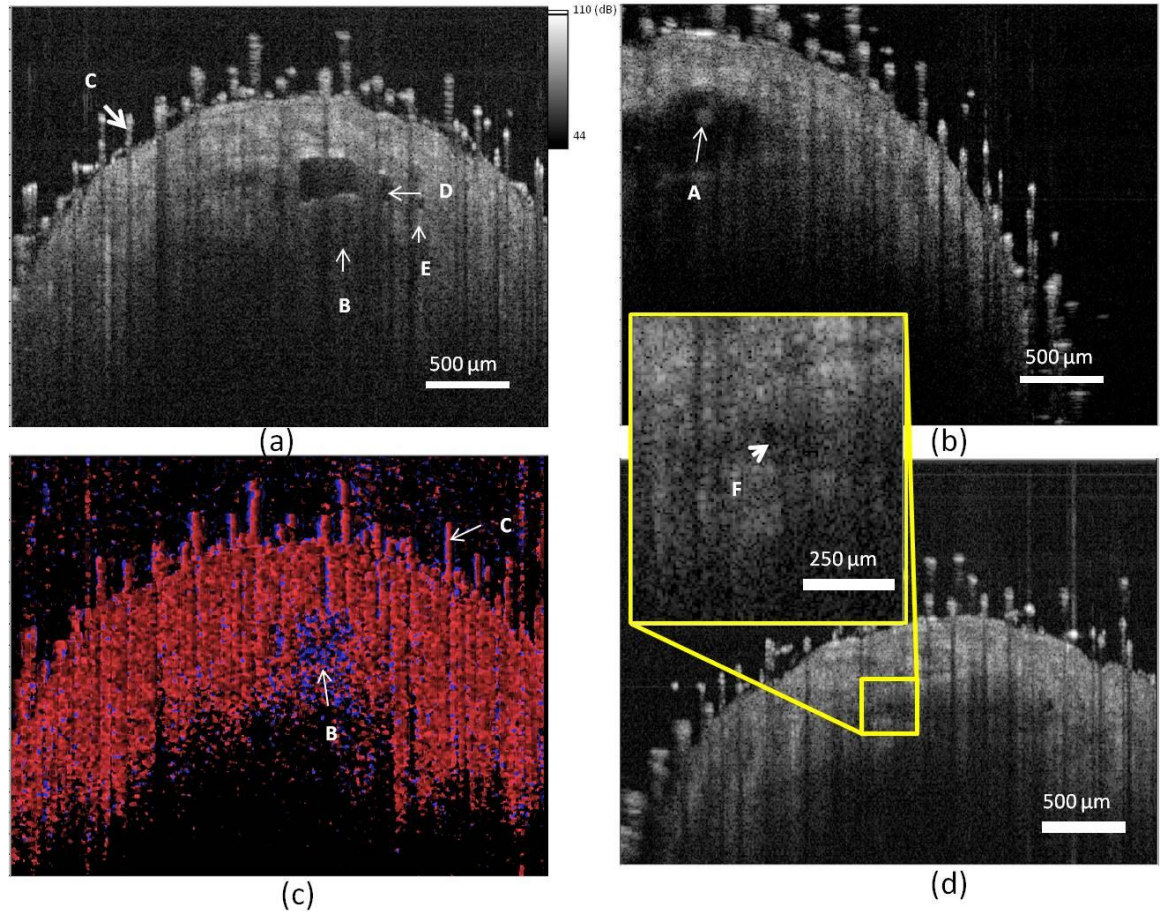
(a) 2D cross section of the tail (b) 2D cross section of the tail showing cluster of bubbles (c) Doppler signal showing the blood flow (d) 2D cross section showing 56 μm microbubble.
